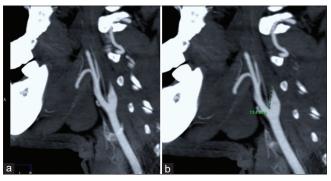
(a) Gradual contrast decline of proximal ICA, (b) Length of opacification of proximal ICA, here it is 13.4 mm. CT = computed tomography, DSA = digital subtraction angiography, ICA = internal carotid artery
